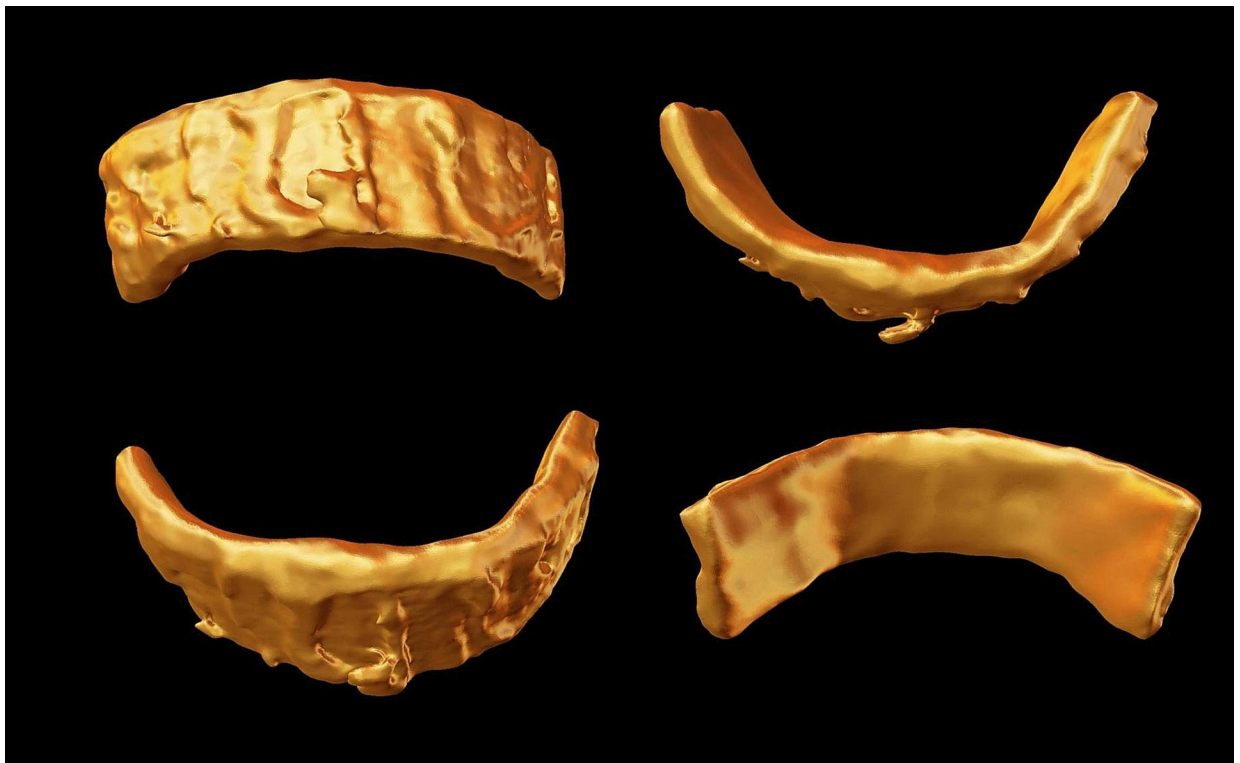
3D CT showing collar-like metallic implant behind neck with relief markings on its outer surface.
